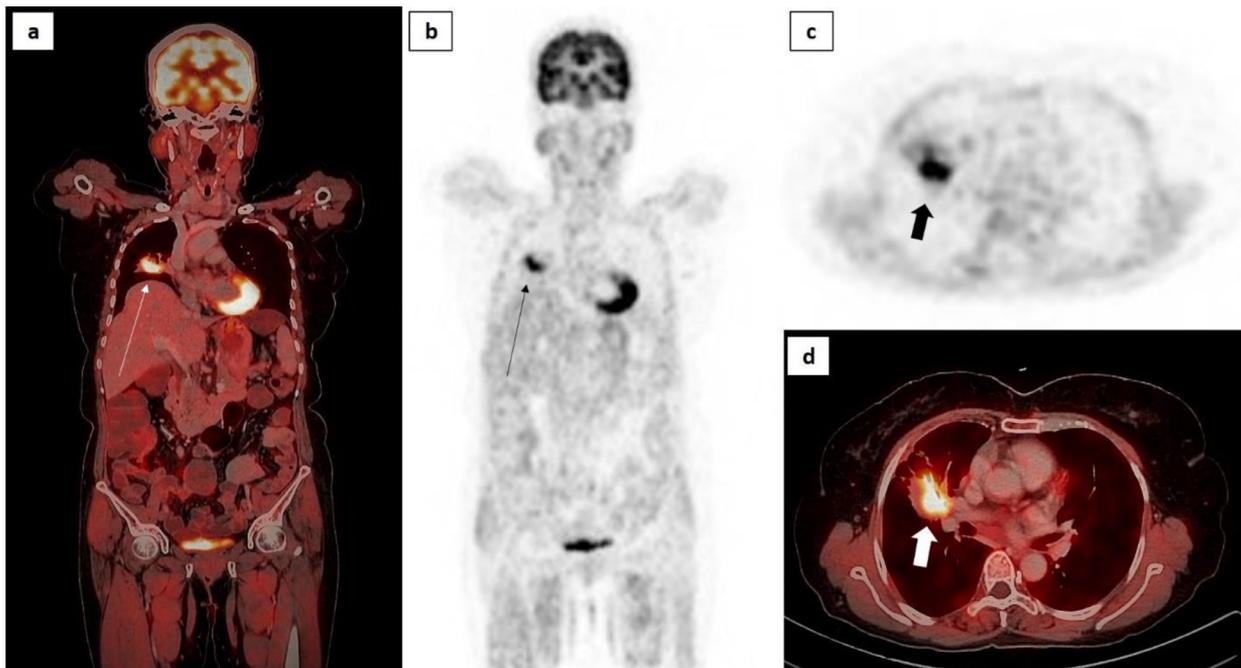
Primary monophasic synovial sarcoma of lung; (B, C) FDG PET scan 3D tracer uptake noted in right lung mass. (Thin long and thick short black arrows) and (A, D) fusion image showing uptake in right lung mass (thin long and thick short white arrows).
